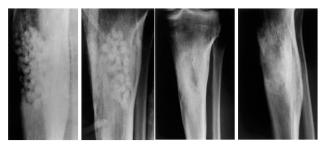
Post operative, and follow up x-rays at 3 and 6 months
